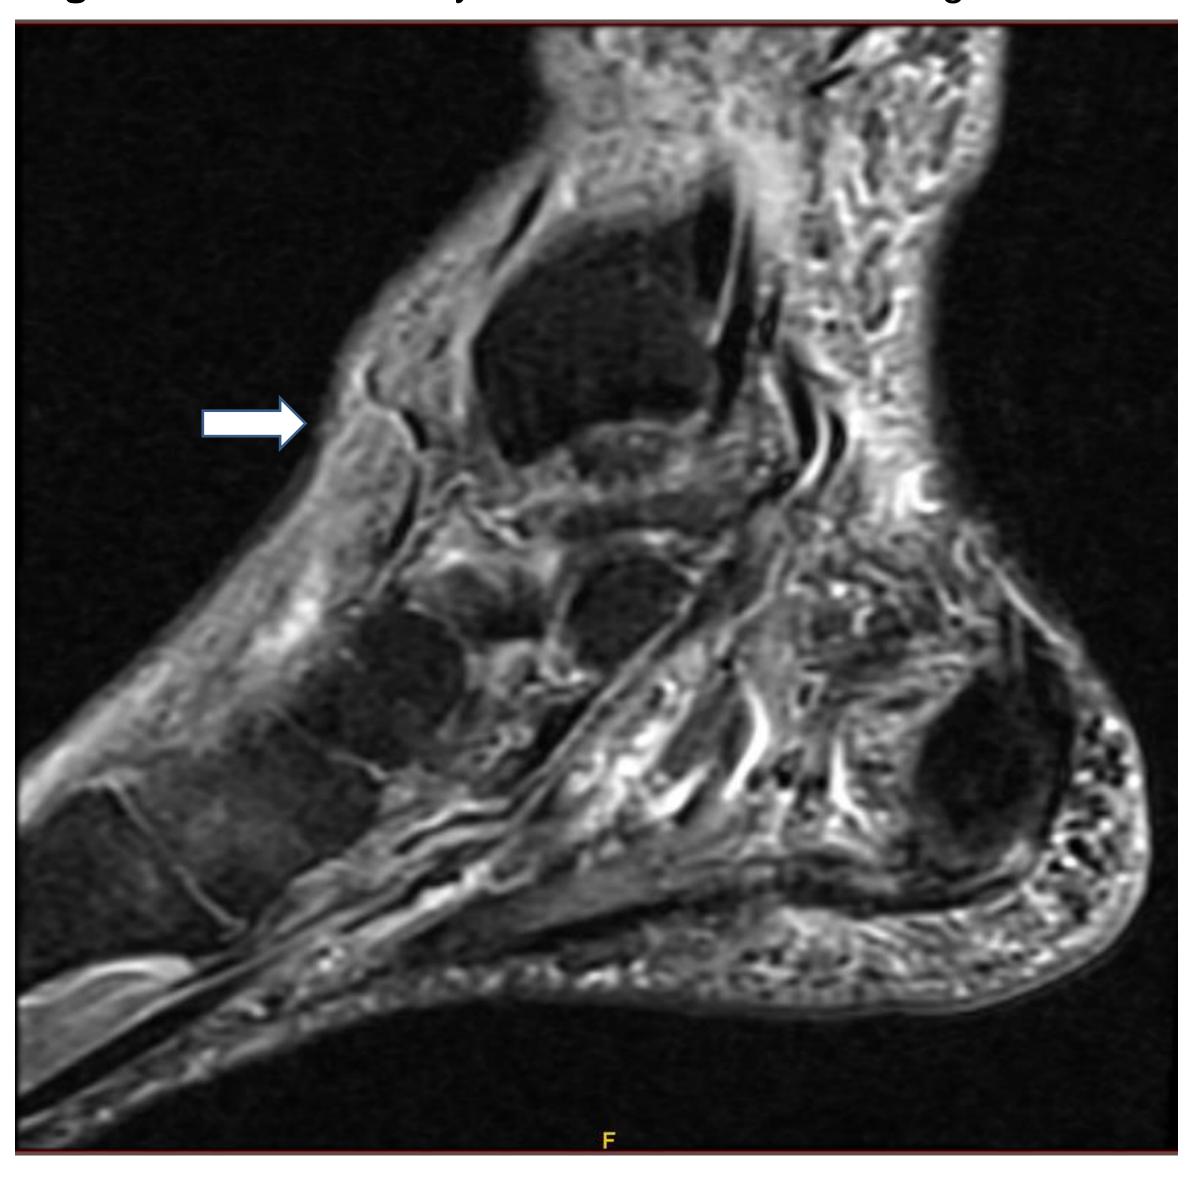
T2 MRI Tibialis anterior tendinosis with 2.7cm rupture and retraction of the thickened, edematous and frayed tendon edge to the level of the talonavicular joint.
